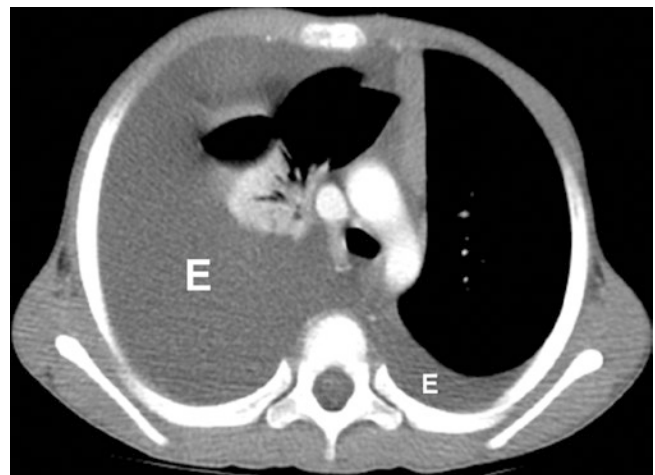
A 4-year-old boy with effusion due to underlying Gorham disease. Enhanced axial CT image shows large right and moderate left effusions (E)
